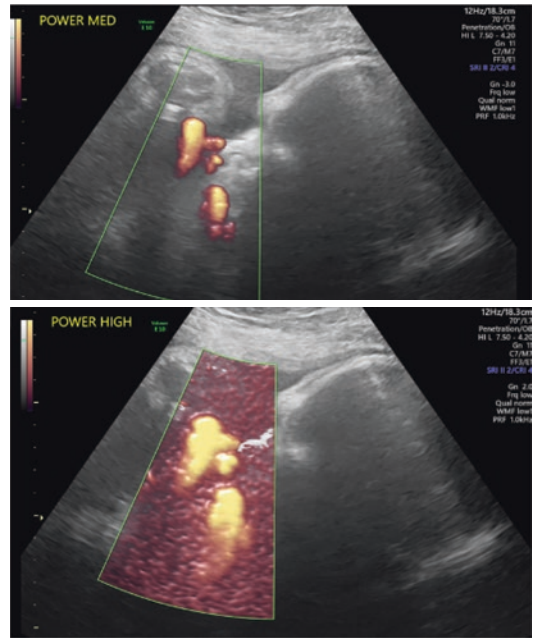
Power Doppler images of umbilical artery demonstrating the effect of increasing the gain from medium (upper panel) to high (lower panel)
